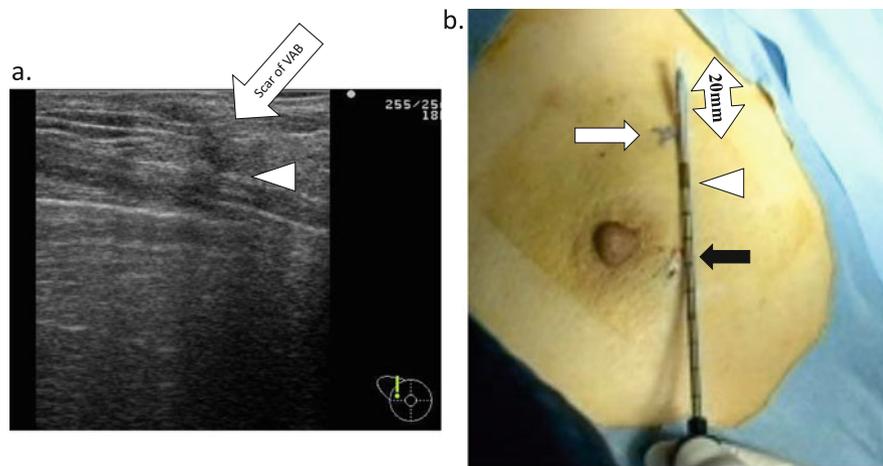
Evaluation of the lesion and the breast before adding incision. (a) Evaluation with ultrasonography. The lesion is barely identified with ultrasonography (*white arrow*) in thin thickness breast. Injection of local anesthesia should be given in the space below the pectoral major fascia (*white arrow head*). After penetration of the lesion with the probe, local anesthesia is administered under the skin. (b) Proper incisional site. Location of the skin surface mark above the lesion (*white arrow*) is 20 mm away from tip of the probe. Incision site (*black arrow*) should be more than 10 mm away from active freezing zone (*white arrow head*)
